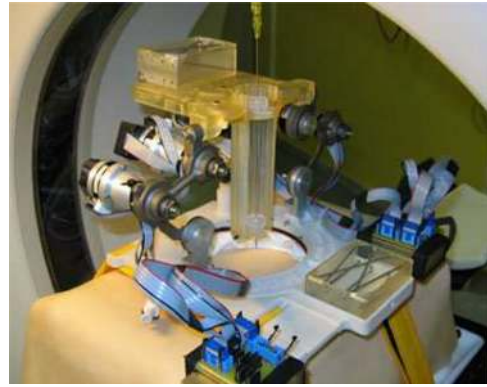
CT-Bot prototype with a passive needle guide.
